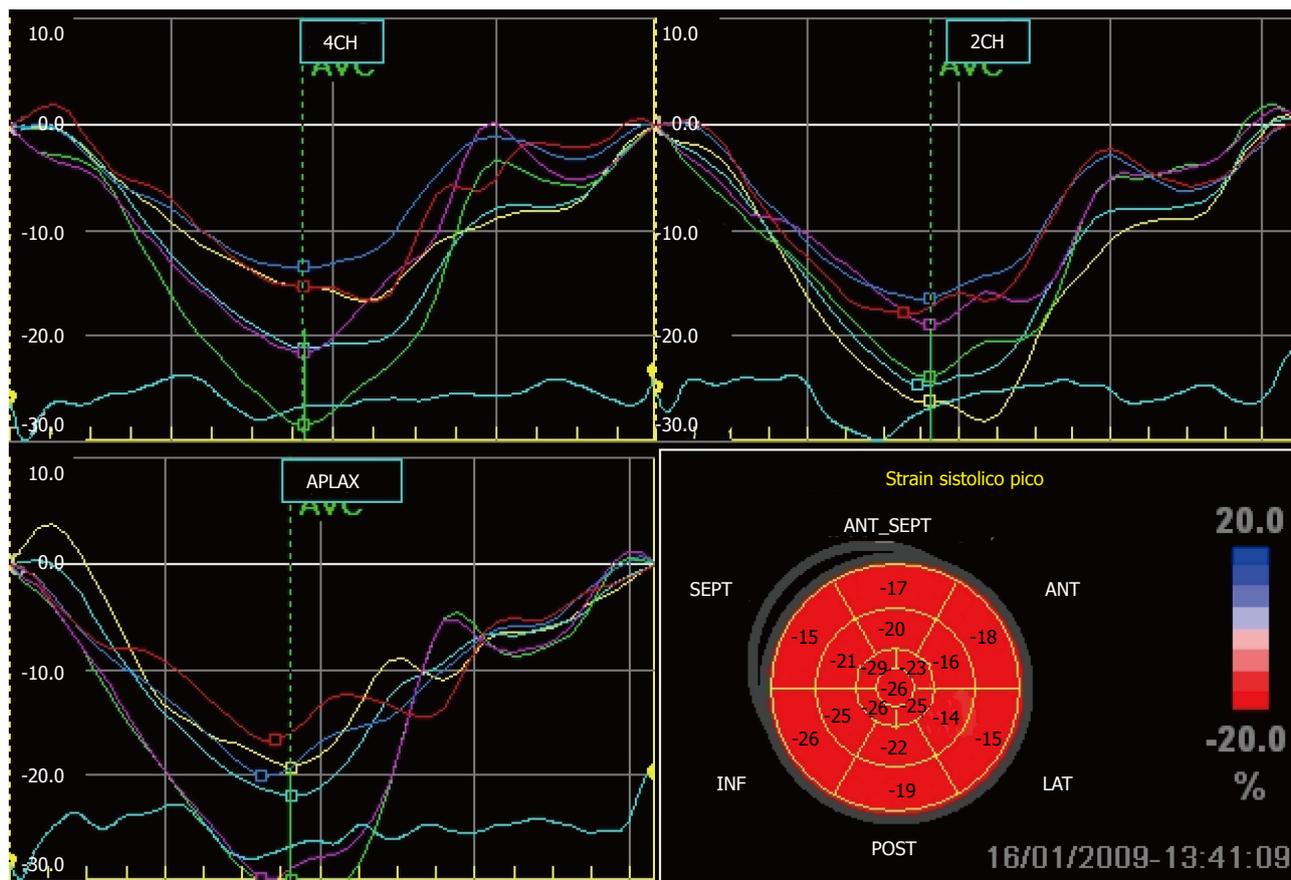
Curves of global longitudinal peak systolic strain from each apical view in a normal subject. Note that in most segments, peak strain occurs during aortic closure. 4CH: Apical 4-chamber; 2CH: Apical 2-chamber; APLAX: Apical long-axis (apical 3-chamber).
